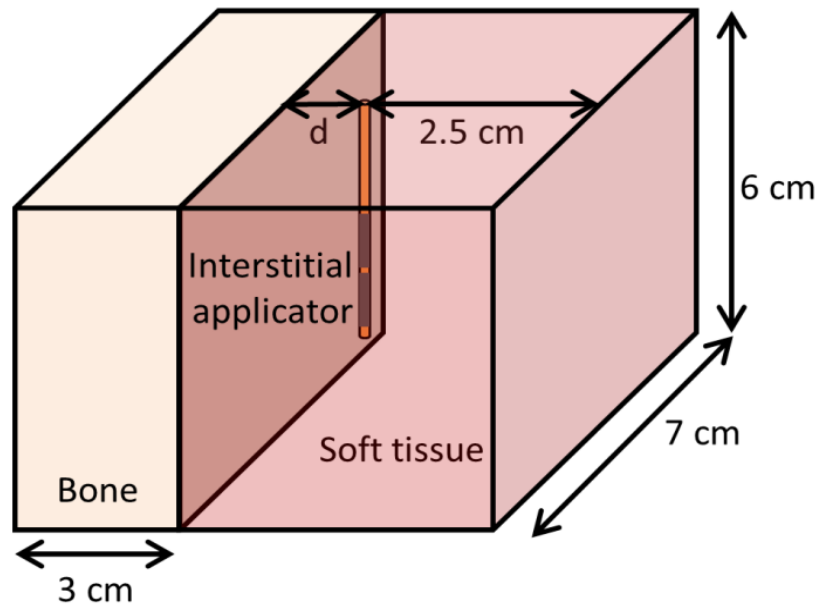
Geometry used to model interstitial ultrasound ablation with the applicator at various distances ($0.5 \text{ cm} \leq d \leq 3.2 \text{ cm}$) from the surface of a flat bone.
